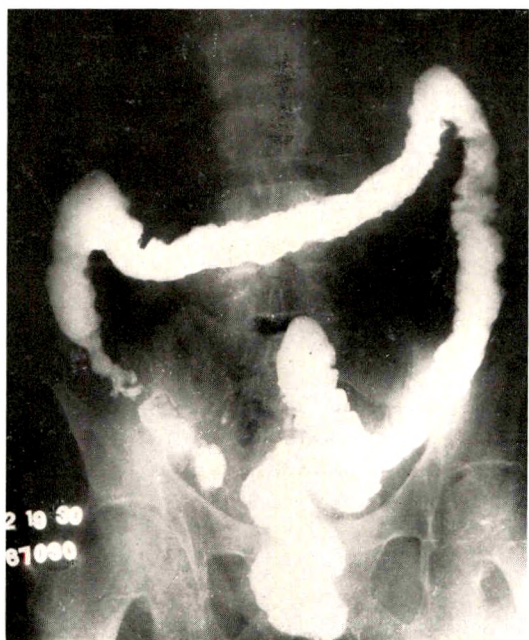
Chronic amebic ulcerative colitis. Narrowing and shortening are confined to the cecum. The terminal portion of the ileum gave no evidence of organic change at roentgenoscopic examination. *Endamoeba histolytica* were found in the stool.
